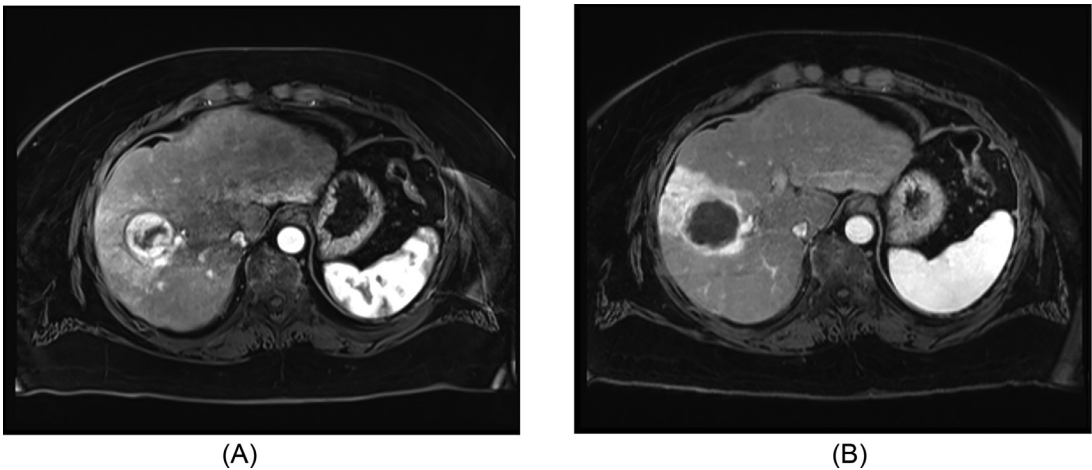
A 57-year-old male with hepatitis C related cirrhosis and a 5.8 cm hepatocellular carcinoma presents for downstaging to transplant (A). The tumor abuts the right hilum and is a poor ablation candidate secondary both size and location. Patient was treated with outpatient segmental ablative radioembolization (radiation segmentectomy) where both the tumor and normal liver compartments within the angiosome received >190 Gy. A 3-month MRI demonstrates mRECIST complete response without injury to the adjacent portal triad or hepatic decompensation (B). Patient remained without evidence of disease, 2 years post treatment, at this time of this publication.
